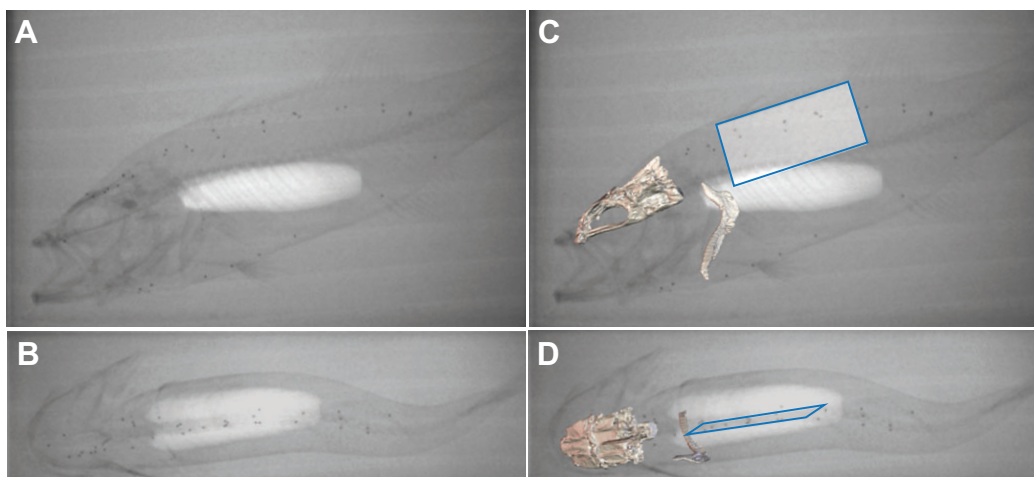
X-ray video frames of suction feeding. Lateral-view (A,C) and ventral-view (B,D) X-ray video frames from a representative strike at peak cleithrum retraction. In C and D, animated bone models and the body plane model (blue outline) have been superimposed on the X-ray frames using X-ray reconstruction of moving morphology (XROMM).
